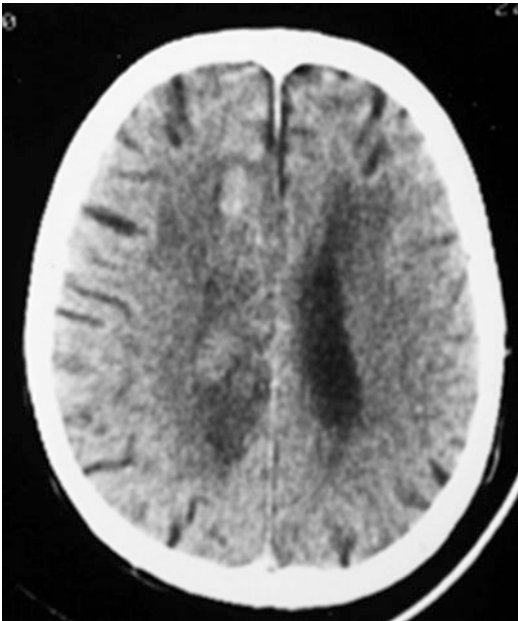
CT scan showing haemorrhagic conversion
